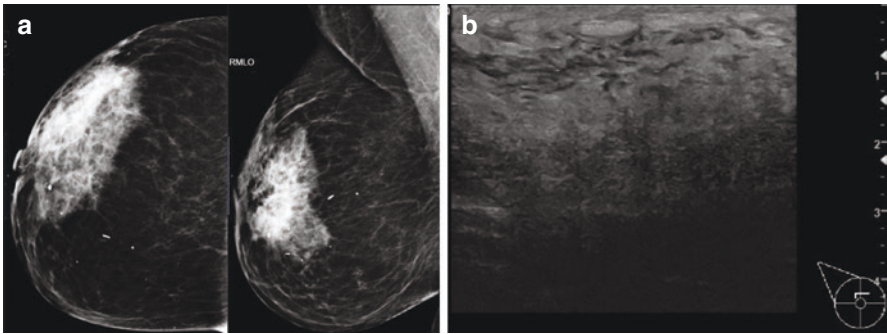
(a) A 53-year-old woman presenting with 60-mm suspicious right retroareolar mass with right retroareolar asymmetry on mammography. (b) Diffuse inflammatory change centrally in the right breast on ultrasound. Core biopsy shows features in keeping with chronic mastitis. Subsequent follow-up confirmed complete clinical and imaging resolution
